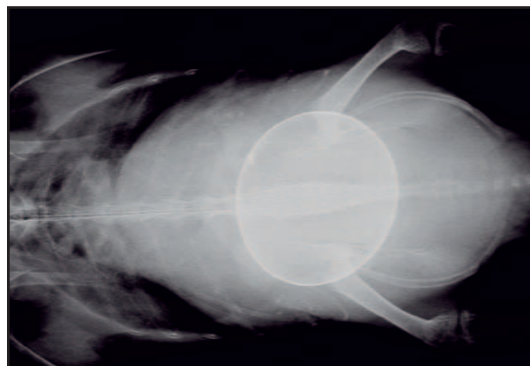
Ventrodorsal radiograph of an ectectus hen with a history of depression and inappetence. Physical examination revealed a distended abdomen and palpable egg in the coelom. Radiographs revealed a calcified egg in the mid coelom.
